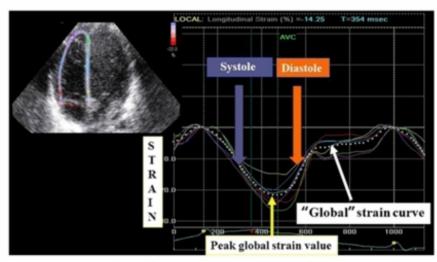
Strain imaging of the RV in an extremely low gestational age neonate with bronchopulmonary dysplasia and increased pulmonary pressure using speckle tracking echocardiography (A). The segmental strain is graphically presented by different color codes and curves and global longitudinal strain by dotted curve with its peak as peak systolic longitudinal strain (B). The segmental strains are not synchronous and peak global longitudinal strain is decreased (-21%, normal >-23%). AVC, aortic valve closure; FR, frame rate.
